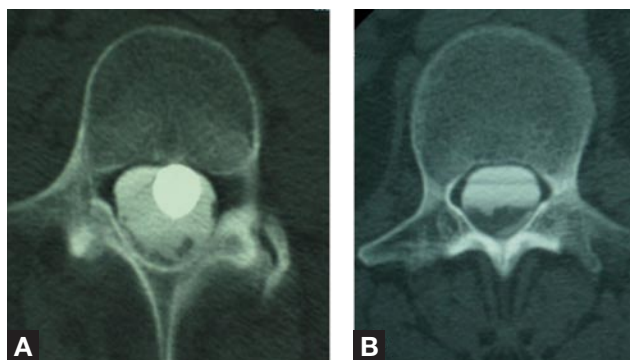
(A) Axial cut of computed tomography (CT) myelogram at L2 pedicle. Note intrathecal nature of missile. (B) Axial cut of CT myelogram shows layering of cerebrospinal fluid with intrathecal contrast, possible organized hematoma, and clumped rootlets consistent with arachnoiditis.
